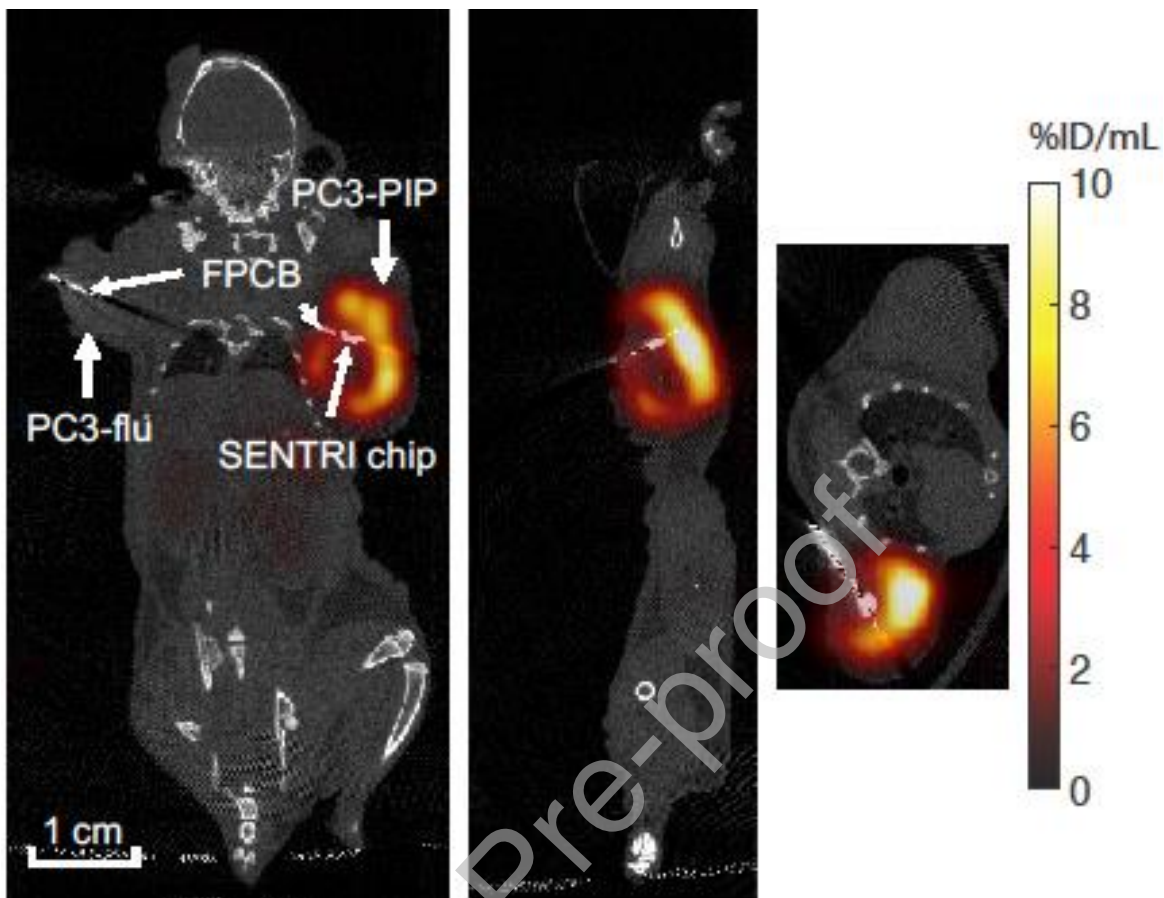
Coronal (left), sagittal (middle), and transverse (right) Gaussian-filtered SPECT/CT images of M6 (7-9 hour time point).
